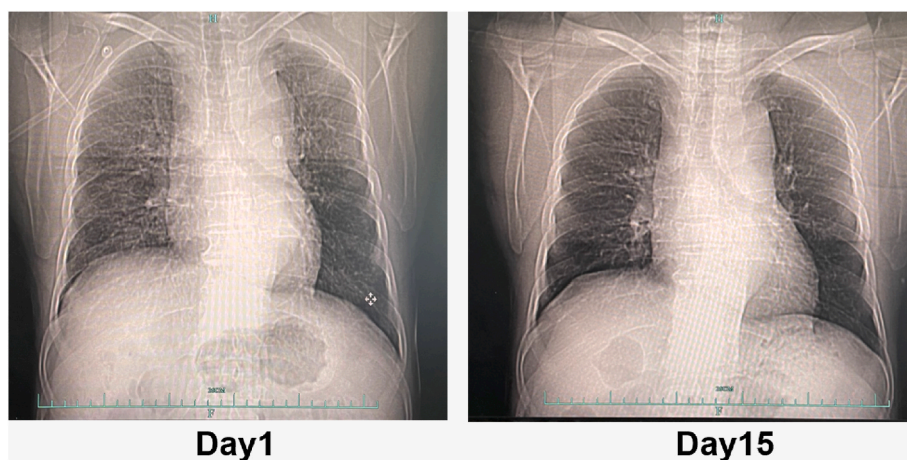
The CT-thorax showing a marked decrease in infiltrative abnormalities after 14 days of treatment.
